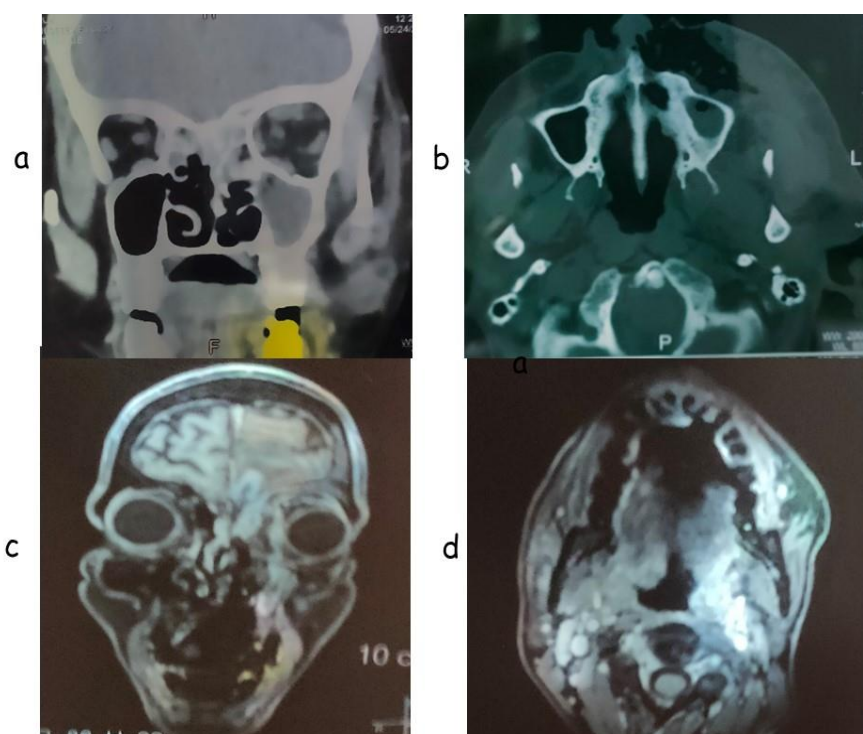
CT and MRI presentation of ROC mucormycosis- (a) coronal section CT, (b) axial section CT, (c) coronal section MRI, (d) axial section MRI
